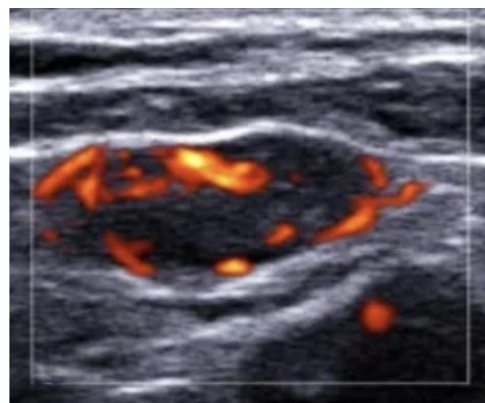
Peripheral Doppler Vascularization of a Cervical Tuberculous Lymph Node
